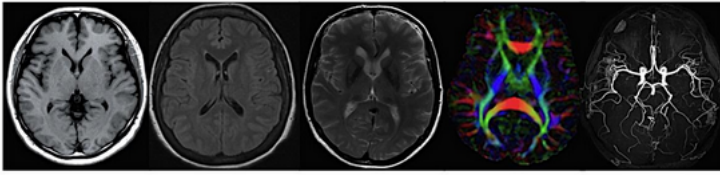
Selection of Image Contrast in MRI.
